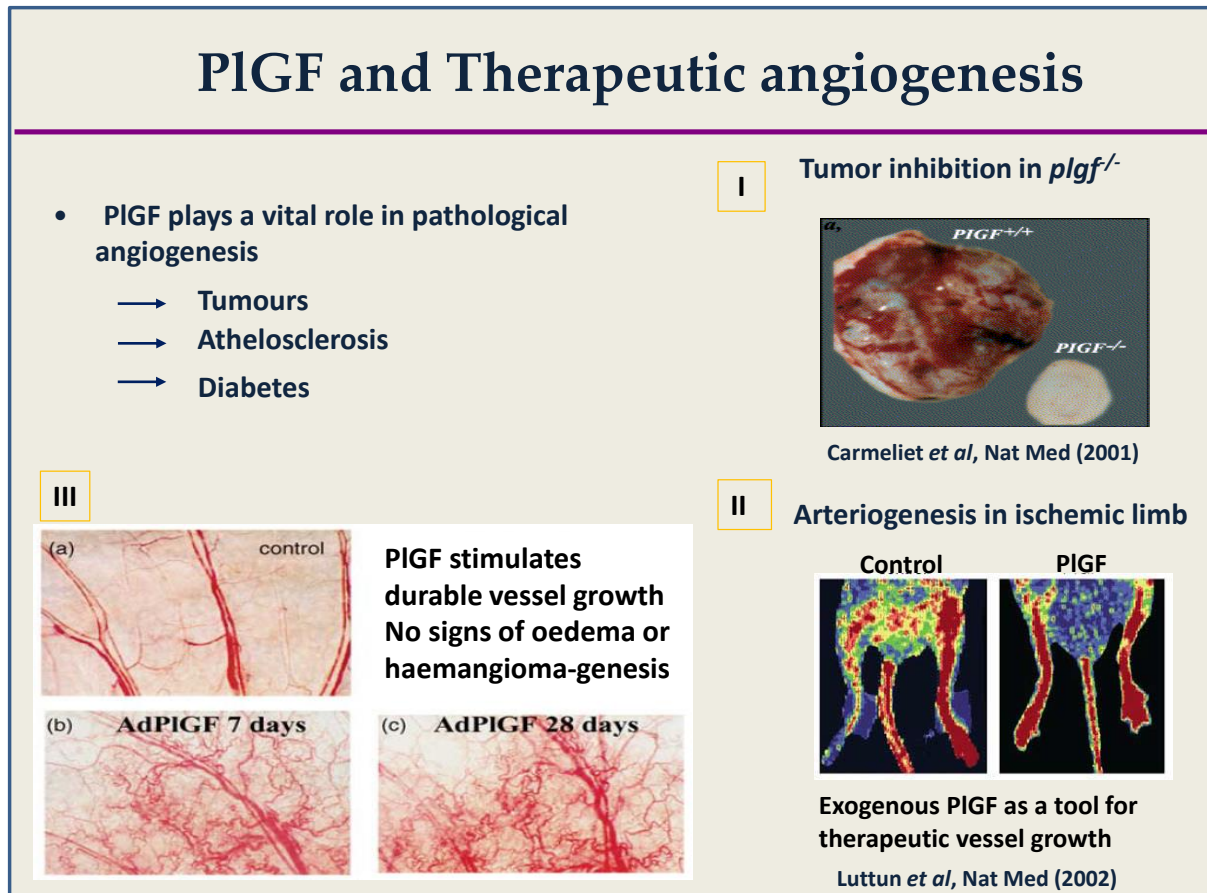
Role of PlGF in therapeutic angiogenesis. (A) Impaired tumour angiogenesis in *Pgf*^{-/-}. Macroscopic pictures of wild-type, *Pgf*^{-/-} [A] ES cell– derived tumours, revealing the haemorrhagic [red] appearance of the large wild-type tumour, in contrast to the small hypovascular [white] *Pgf*^{-/-} tumours (Carmeliet, Moons *et al.* 2001). Laser Doppler imaging, revealing that perfusion through the ligated right limb seven days after femoral artery ligation is increased by treatment with hPlGF-2 (Luttun, Tjwa *et al.* 2002).
